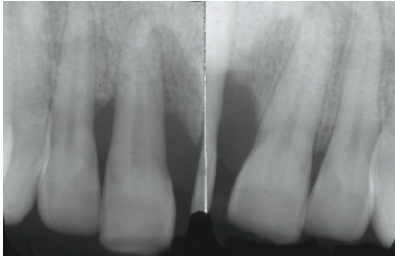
The baseline radiograph shows the presence of a deep and wide intrabony defect involving the mesial and also the distal side of tooth 11.
